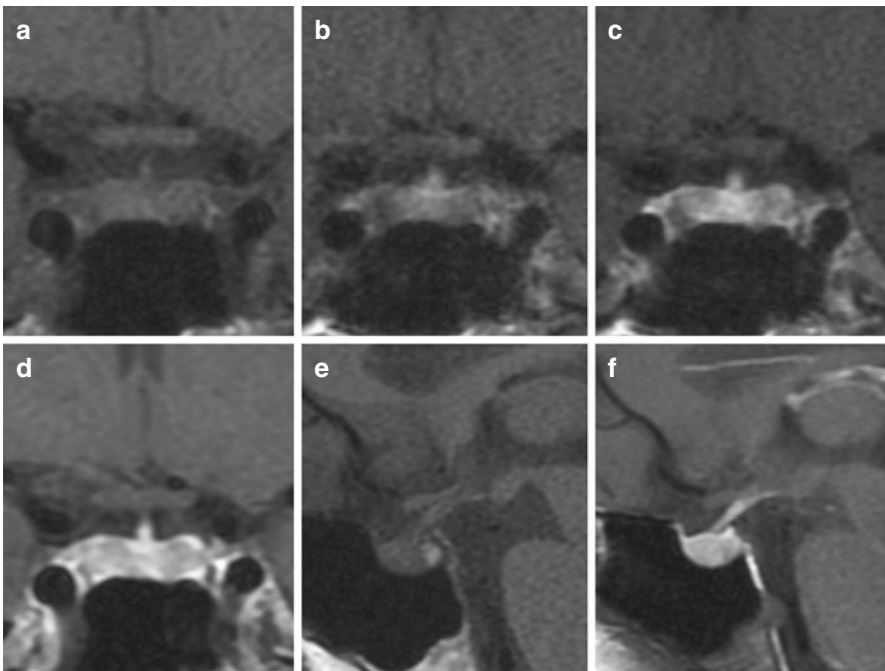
Normal pituitary MRI with a small field of view. (a–d) Dynamic post-contrast T1-weighted coronal imaging shows progressive enhancement that begins with the infundibulum, and progressively fills the pituitary from central to peripheral. (e) Non-contrast T1-weighted sagittal imaging shows the normal appearance of the posterior pituitary bright spot. (f) Delayed post-contrast T1-weighted sagittal imaging shows homogeneous enhancement of the pituitary and infundibulum
